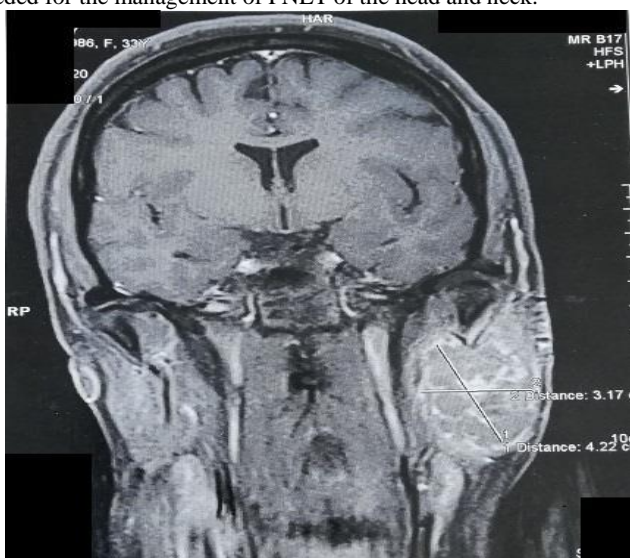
Magnetic resonance imaging (MRI) of head-neck showed a soft-tissue mass of heterogenous density in the left side of the parotid gland
